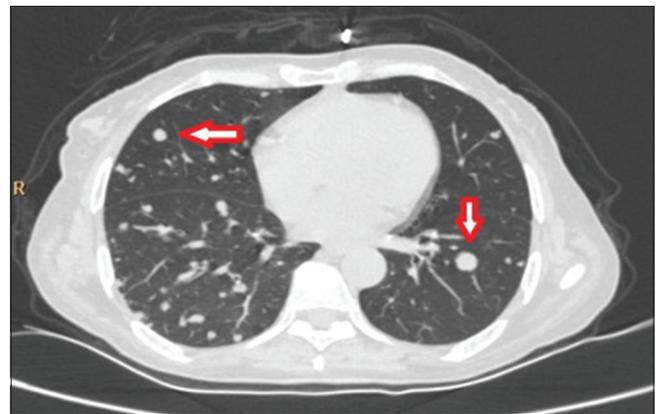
Computed tomography scan image showing metastases to lung
